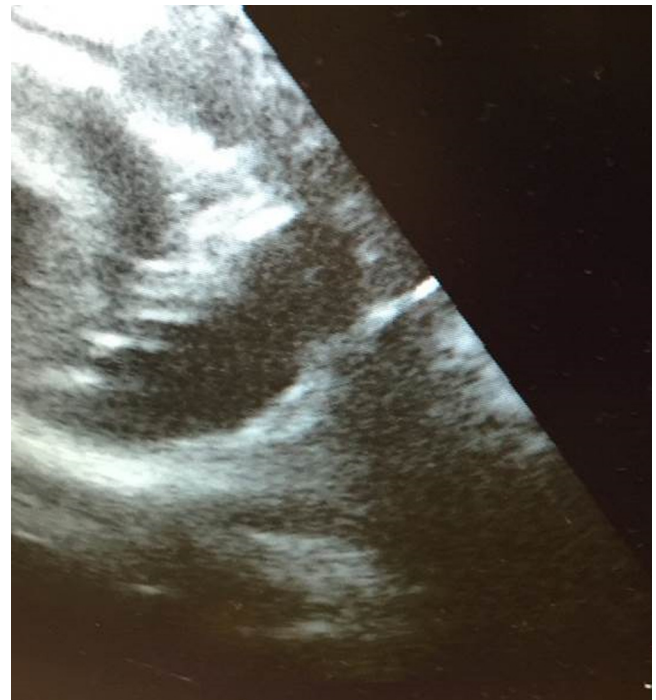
A bedside ultrasound demonstrating a pericardial effusion.
